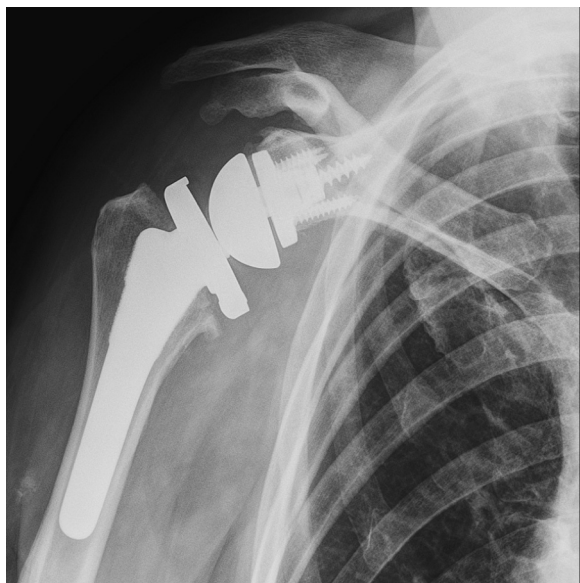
Radiograph depicting reverse total shoulder arthroplasty (frontal view).
